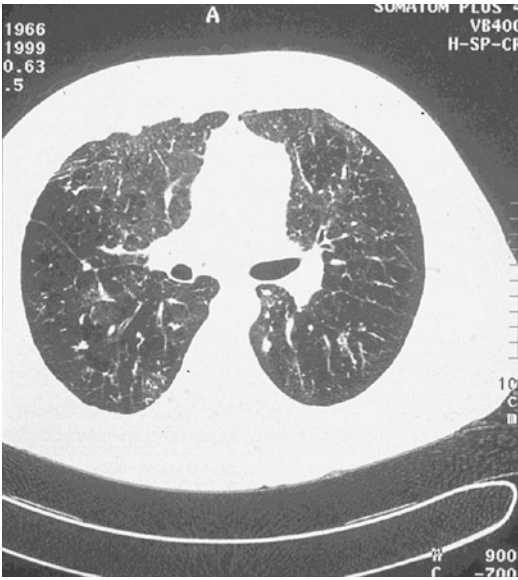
Pulmonary findings of LCH on chest CT
